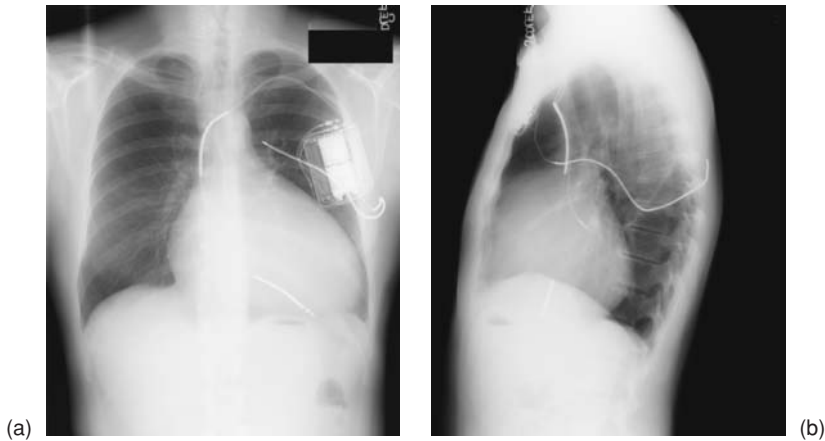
Marked cardiac enlargement noted by (a) anteroposterior and (b) lateral chest radiography in a patient with advanced Ebstein's anomaly. Note the internal cardioverter defibrillator device and leads. The patient underwent assessment for syncope and was found to have inducible ventricular tachycardia. A device was placed. Despite ventricular tachycardia, the patient was not referred for congenital consultation or cardiac surgical intervention until he had severe symptoms of right heart failure, several years later.
